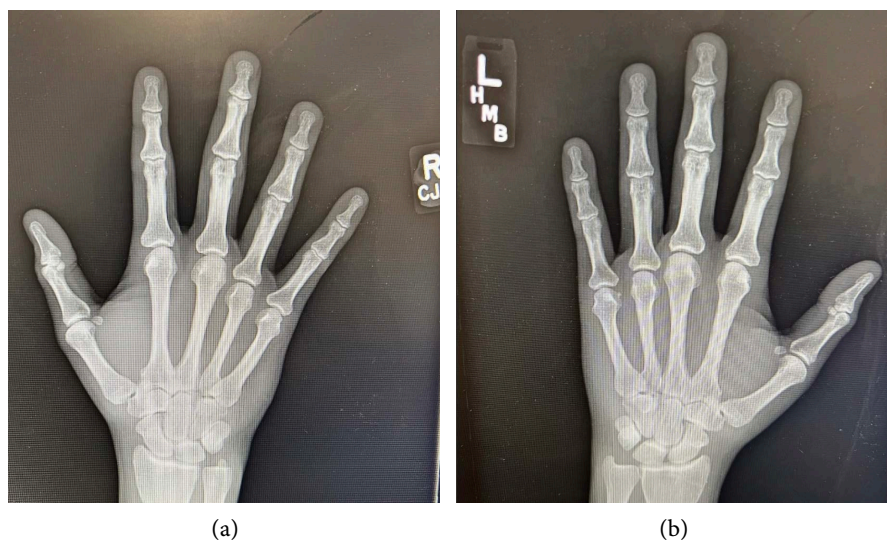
(a): Right hand X-ray; (b): Left hand X-ray.
